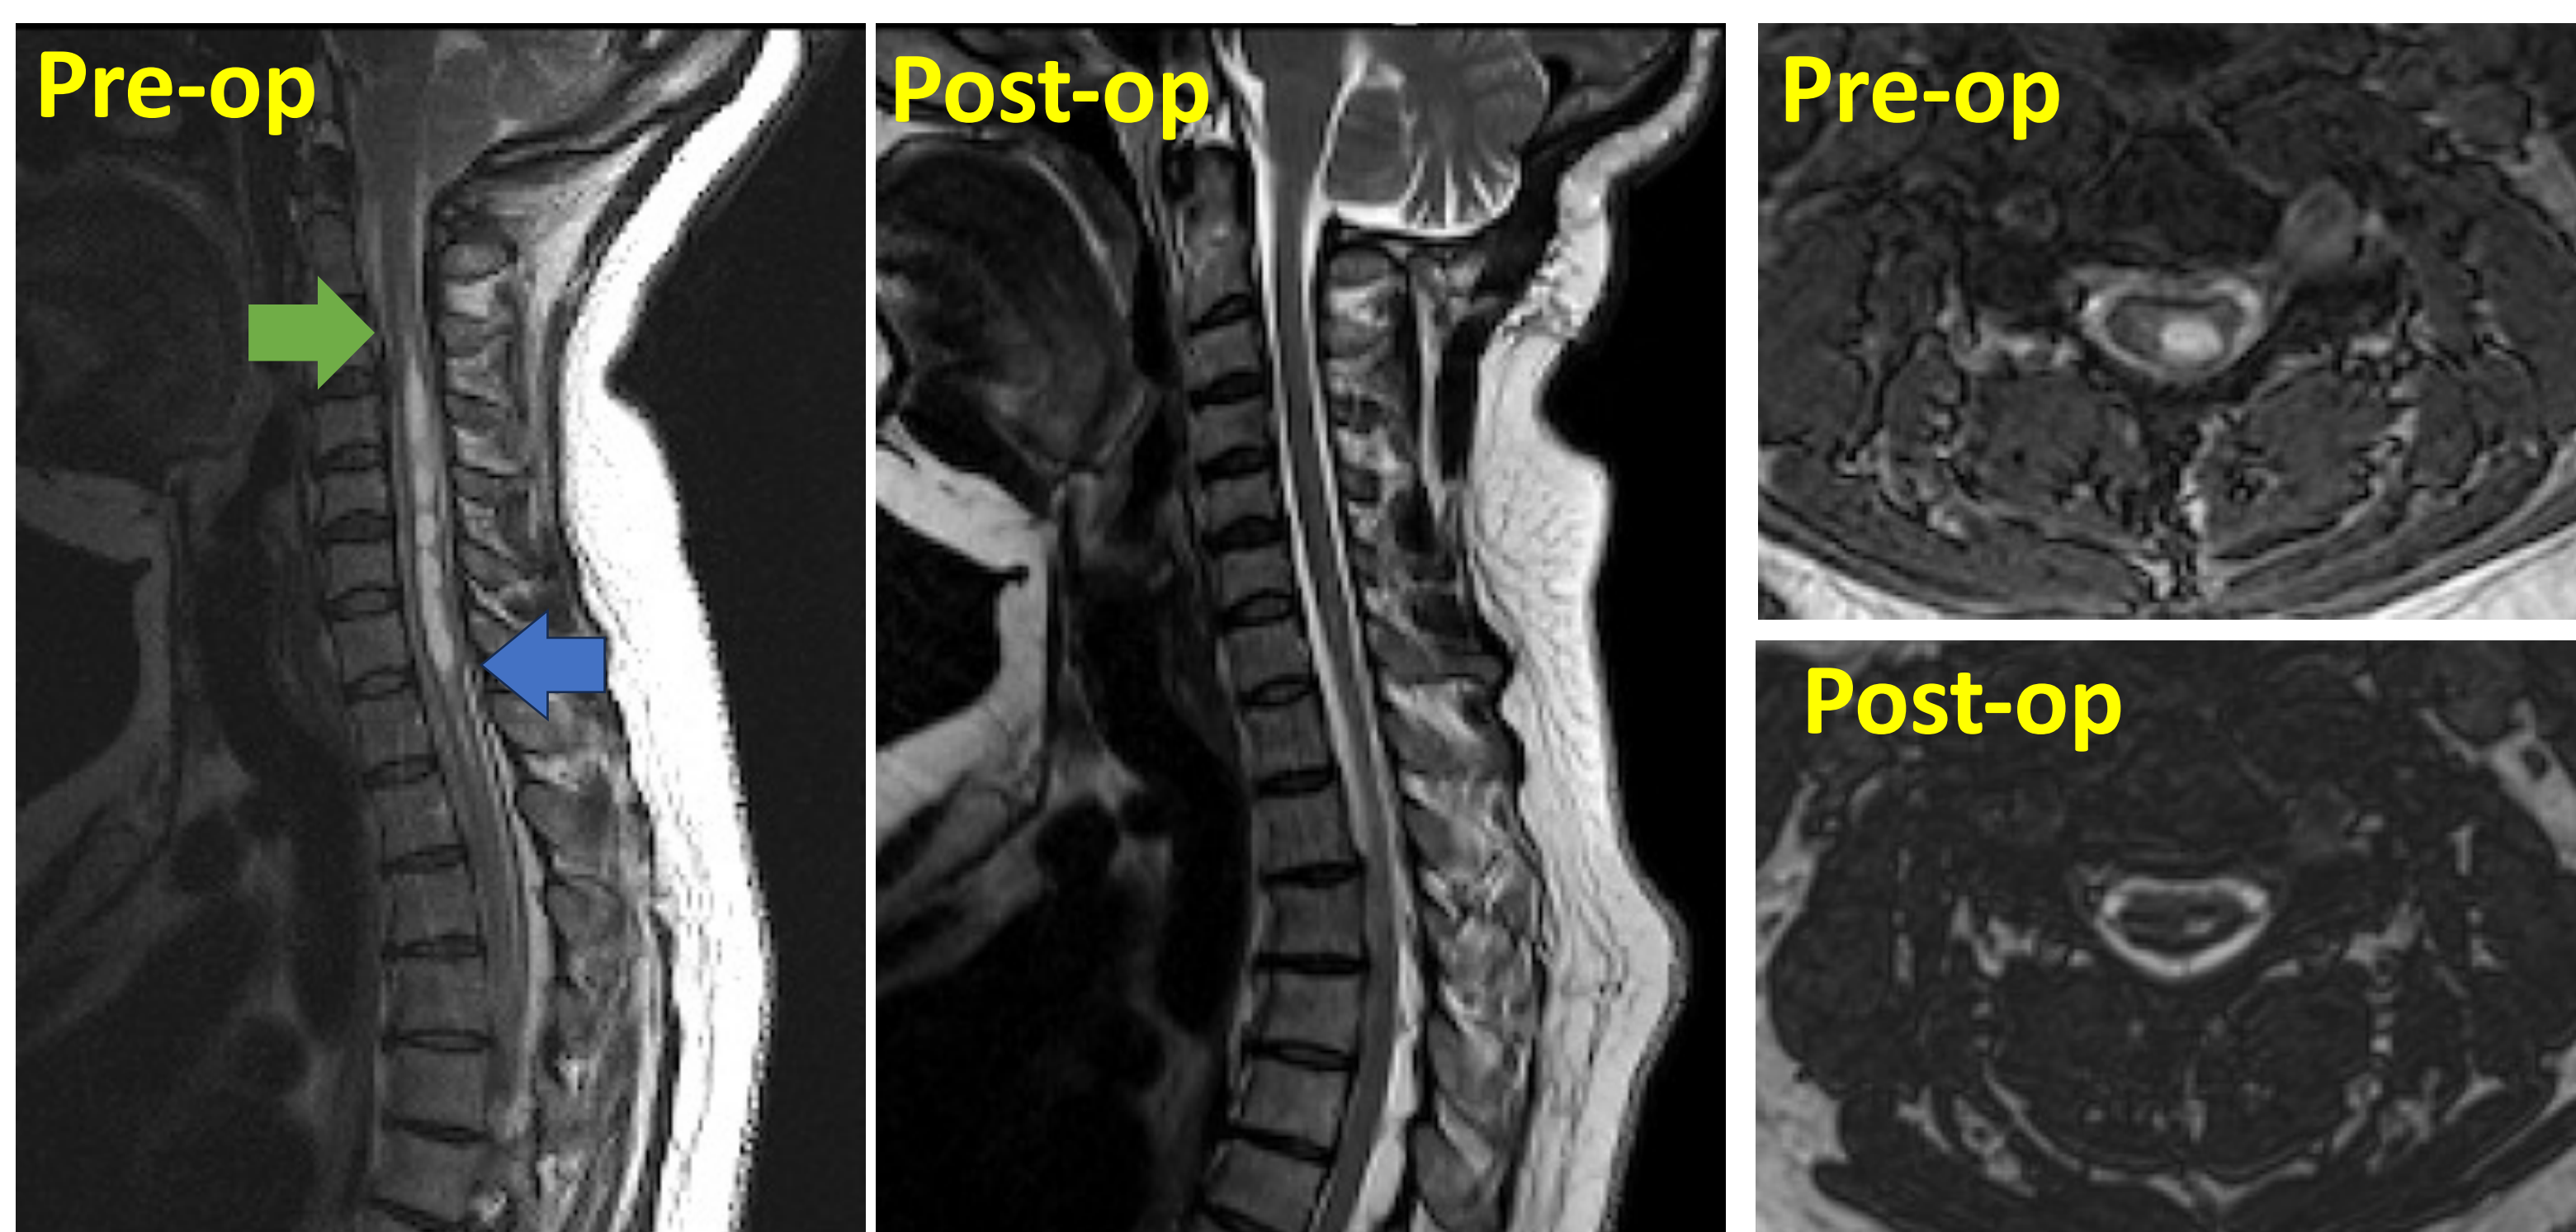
MRI scans before and after treatment by decompression surgery. Sagittal (left) & axial MRI images (C4 segment) (right) of the cervical spine.
